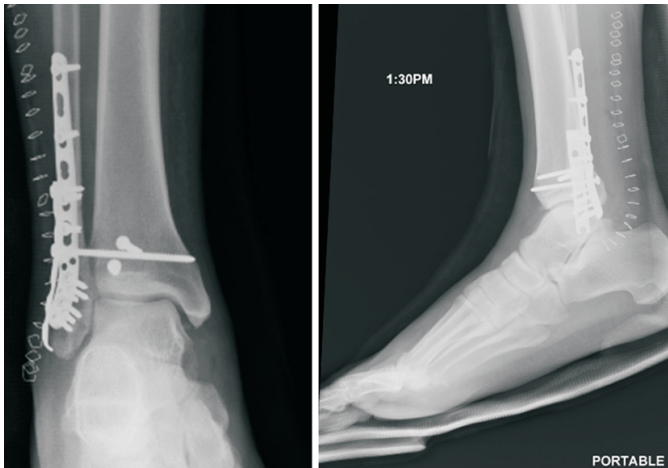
Postoperative anteroposterior and lateral radiographs of a bimalleolar equivalent ankle fracture with double plating of the comminuted fibular fracture, open reduction with internal fixation of a posterior malleolar fracture, and lagged syndesmosotic fixation.
